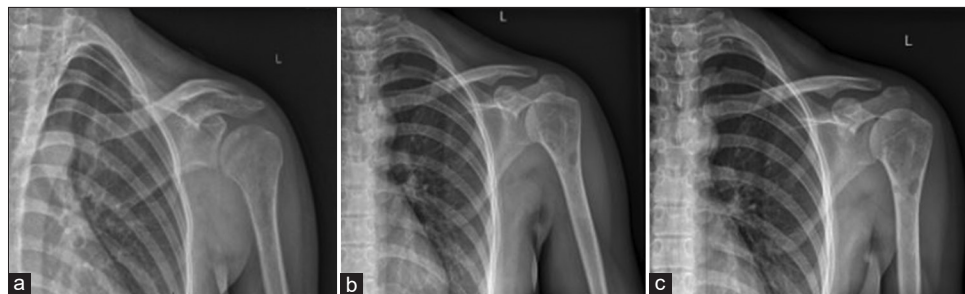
Comparison of shoulder radiographs (a) during initiation of oral steroid therapy, (b) after 8 months postoral steroid therapy, (c) after 1 year postoral steroid therapy
